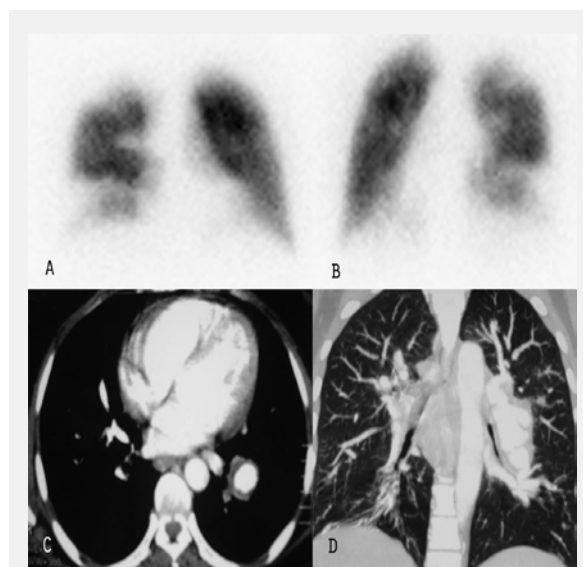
Segmental and subsegmental perfusion defects in left and right lungs were observed on anterior (A) and posterior (B) perfusion lung scintigraphy images of a 33-year-old female patient. CT angiography of this patient shows non-occlusive huge aneurysmatic pulmonary arteries on axial (C) and coronal (D) images. This patient is an example of “pulmonary artery aneurysm without thrombosis” (Gr-1a). She received intense immunosuppressive treatment without anticoagulation. She is now asymptomatic after 10 years of first presentation with low-dose immunosuppressive after two exacerbation of pulmonary involvement when she was on remission without any treatment.
